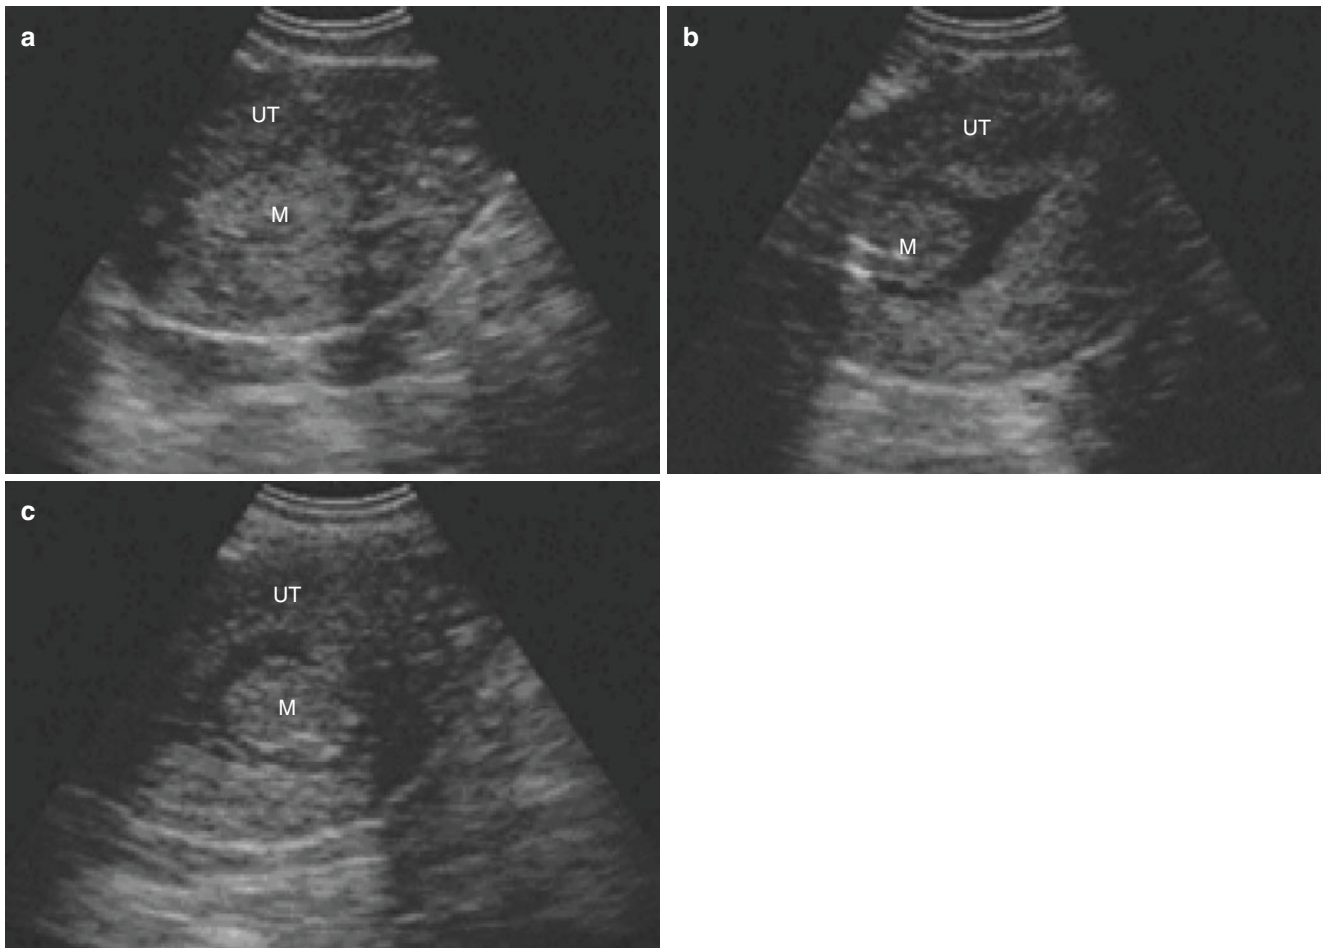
Sonohysterography of single endometrial polyp (I) (a). The patient is 41 years old and have menorrhagia for more than one year. Transvaginal ultrasound examination of the uterine cavity shows a hyperechoic mass. (b). After injection of contrast agent, a hyperechoic
